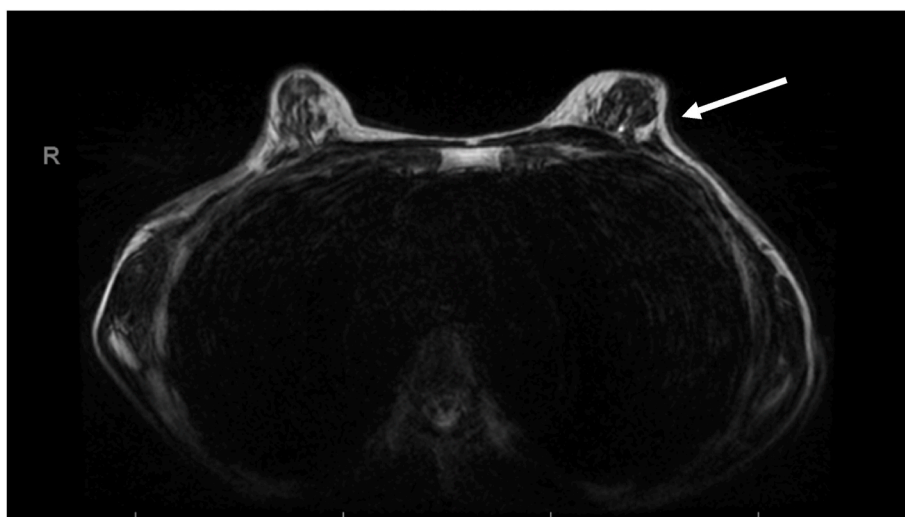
MRI of both breasts. Malignant lesion in left breast marked with an arrow.
